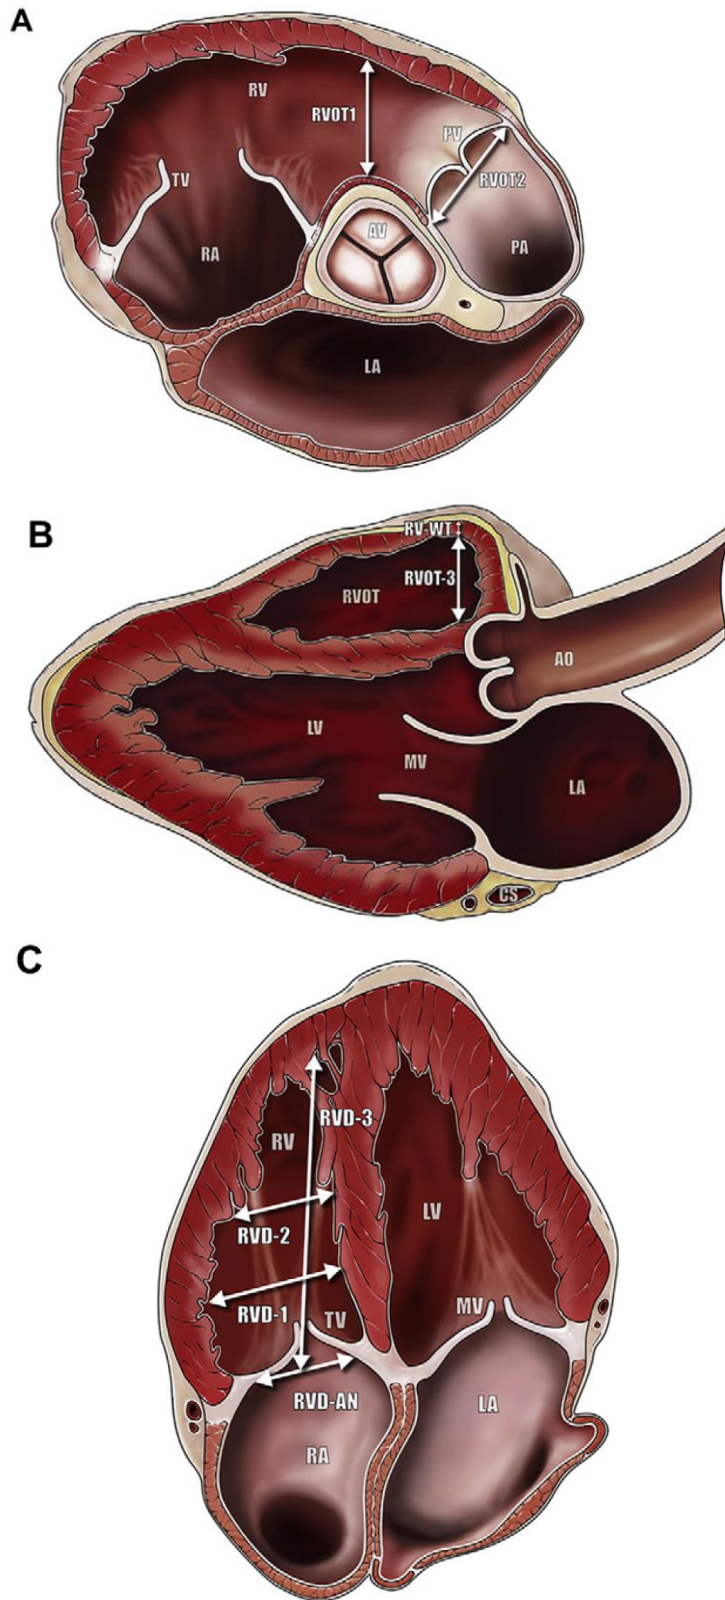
Sample images showing measurements of the RV at end diastole. (A) Sample images representing views and measurements from the parasternal short axis view at the aortic valve level showing RVOT-1 and RVOT-2. (B) Parasternal long axis view showing RVOT-3 and RV WT. (C) Apical four chamber view. Within this view, assessment in the major and minor axis is possible. RVESA and RVEDA are also made from this view.
